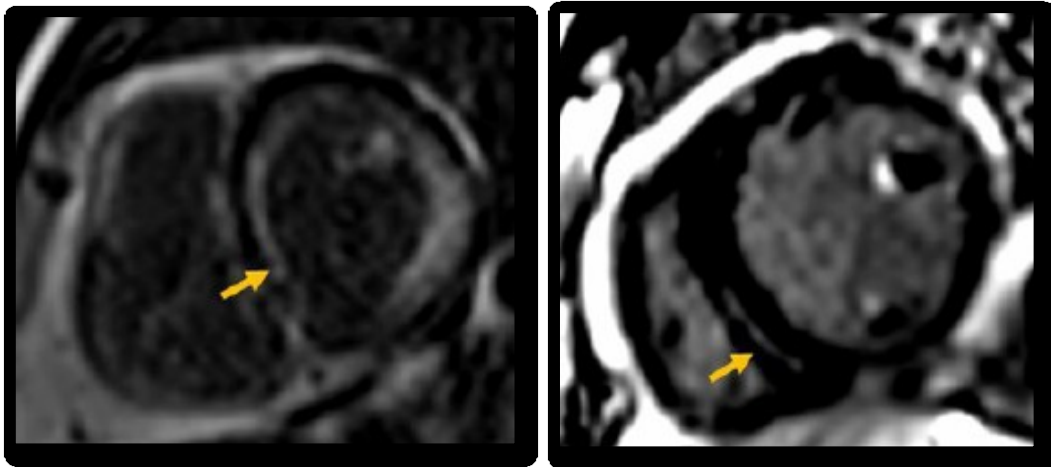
Late gadolinium-enhanced (LGE) MR images: Global subendocardial LGE in Amyloidosis (Left), Midwall LGE in Dilated cardiomyopathy (Right)
